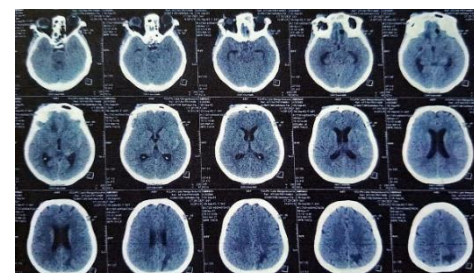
The second Head CT scan in Hospital
